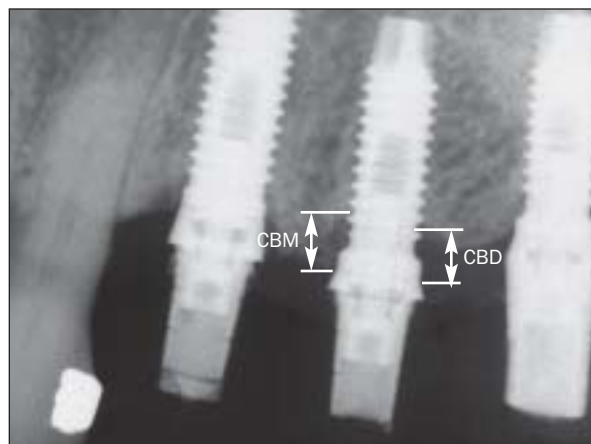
Radiographic measurement of bone level changes. CBM = the distance between the implant shoulder and the mesial bone level. CBD = the distance between the implant shoulder and the distal bone level.
